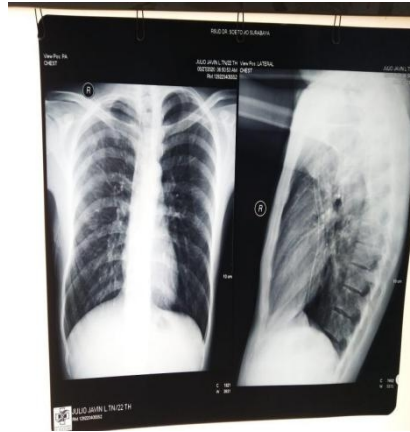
Chest X-ray on seventh-day lungs still appear to have expanded after a 48-hour thoracic clamp, and the infiltrates in the right lung have disappeared.
